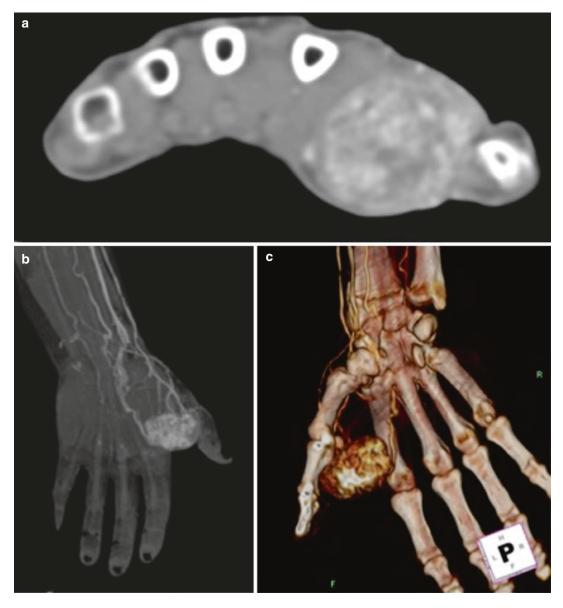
Arteriovenous malformation (AVM). (a) Axial CT, postcontrast.(b) coronal reconstruction of CT angiogram. (c) 3D reconstruction. AVM in the first web space (Image courtesy F.M. Vanhoenacker)
